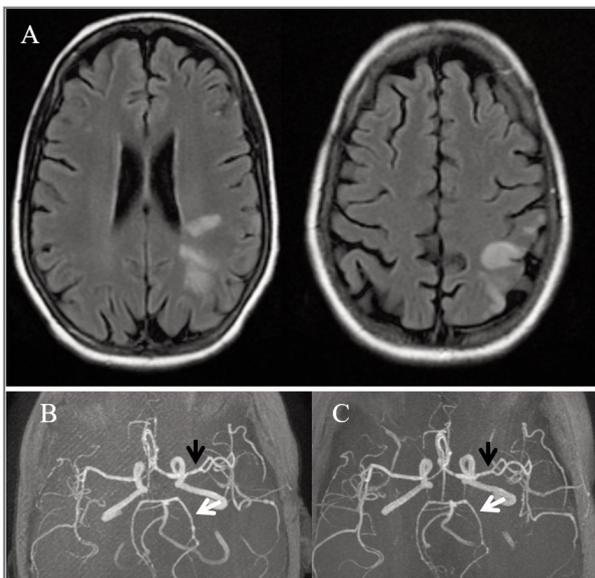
A (MRI in T2 FLAIR sequence) shows multiple ischemic lesions in different vascular territories, suggesting cerebral vasculitis. B (MRI in TOF sequence) shows segmental narrowing and irregularity of left middle (black arrow) and left posterior arteries (white arrow), with caliber improvement one month later (C), after treatment with cyclophosphamide and rituximab
